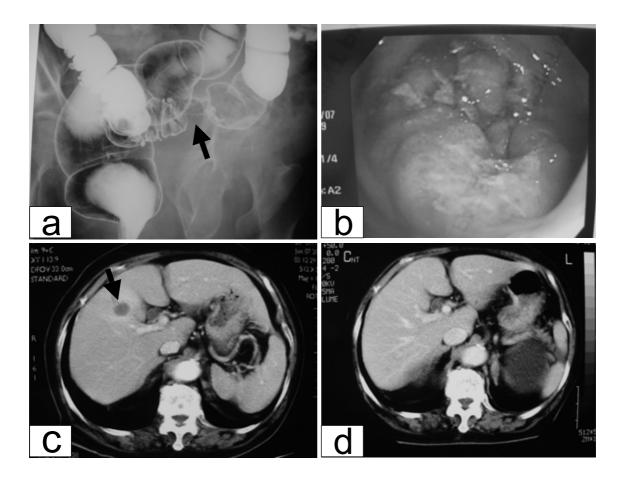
a: Double-contrast barium enema image showing a space-occupying lesion in the sigmoid colon (arrow). b: Colonoscopy disclosed a sigmoid colonic tumor. Biopsy showed moderately differentiated adenocarcinoma. c: Computed tomography (CT) scan showing one of the liver abscesses (in the right lobe) before the operation (arrow). d: Six days after the operation, CT showed progressive improvement of the focal liver lesions together with subjective and clinical improvement.
